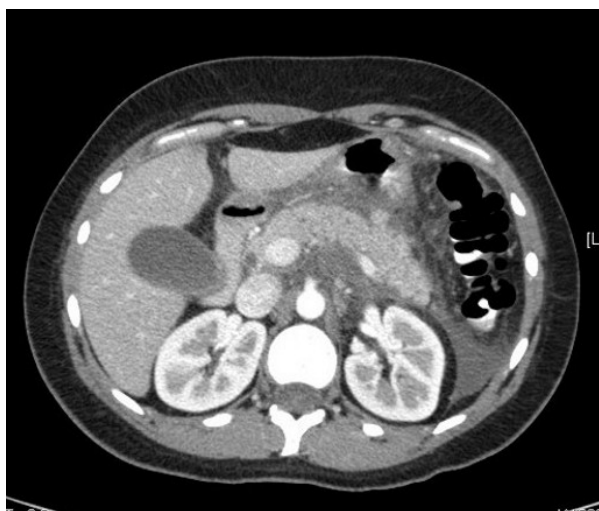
Extensive peripancreatic inflammatory changes and stranding is evident on the CT image shown here. Fluid is seen in the pericolic gutter and surrounding the liver.
